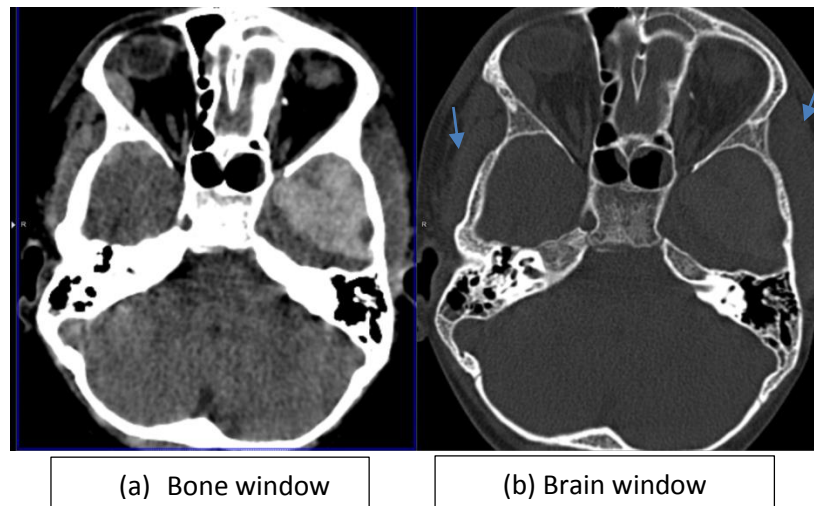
Non -contrast Computed Tomography (NCCT) head showing extra-axial hemorrhages (arrows) along right and left temporal convexity while bone window showing normal bone scan
